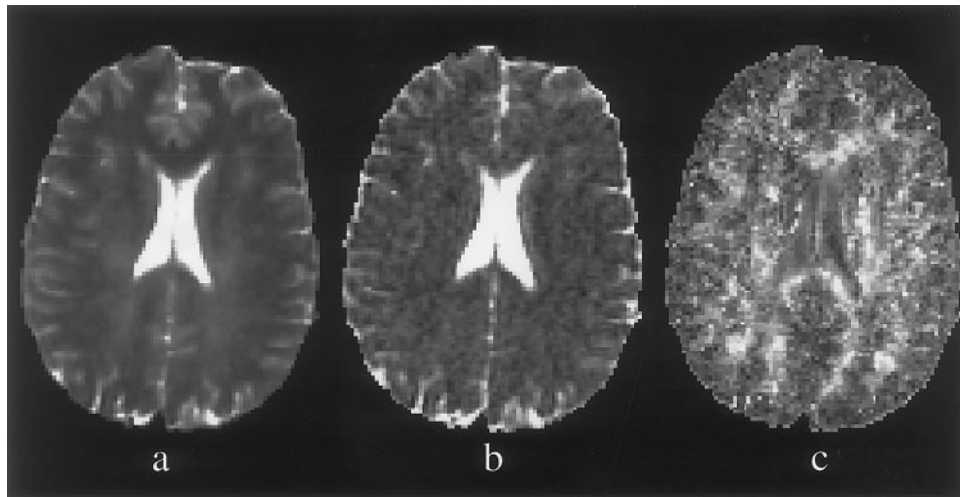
Typical T2-weighted (a), trace (b), and fractional anisotropy (c) images obtained from a control. On the trace image, diffusion is seen to be greatest in the CSF-filled ventricles and sulci, where there is little restriction to diffusion, and lower in tissue. Regions where the tissue is highly ordered appear brighter on the fractional anisotropy image (eg, corpus callosum). Regions where diffusion is effectively isotropic, such as in the ventricles, have lower intensity.
